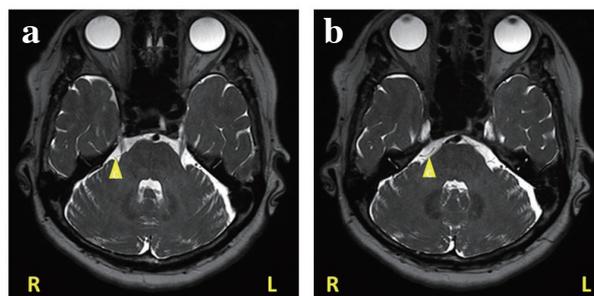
a, b: MRI scans showing compression of the right trigeminal nerve (RTN) by the superior cerebellar artery (SCA). R: right, L: left
